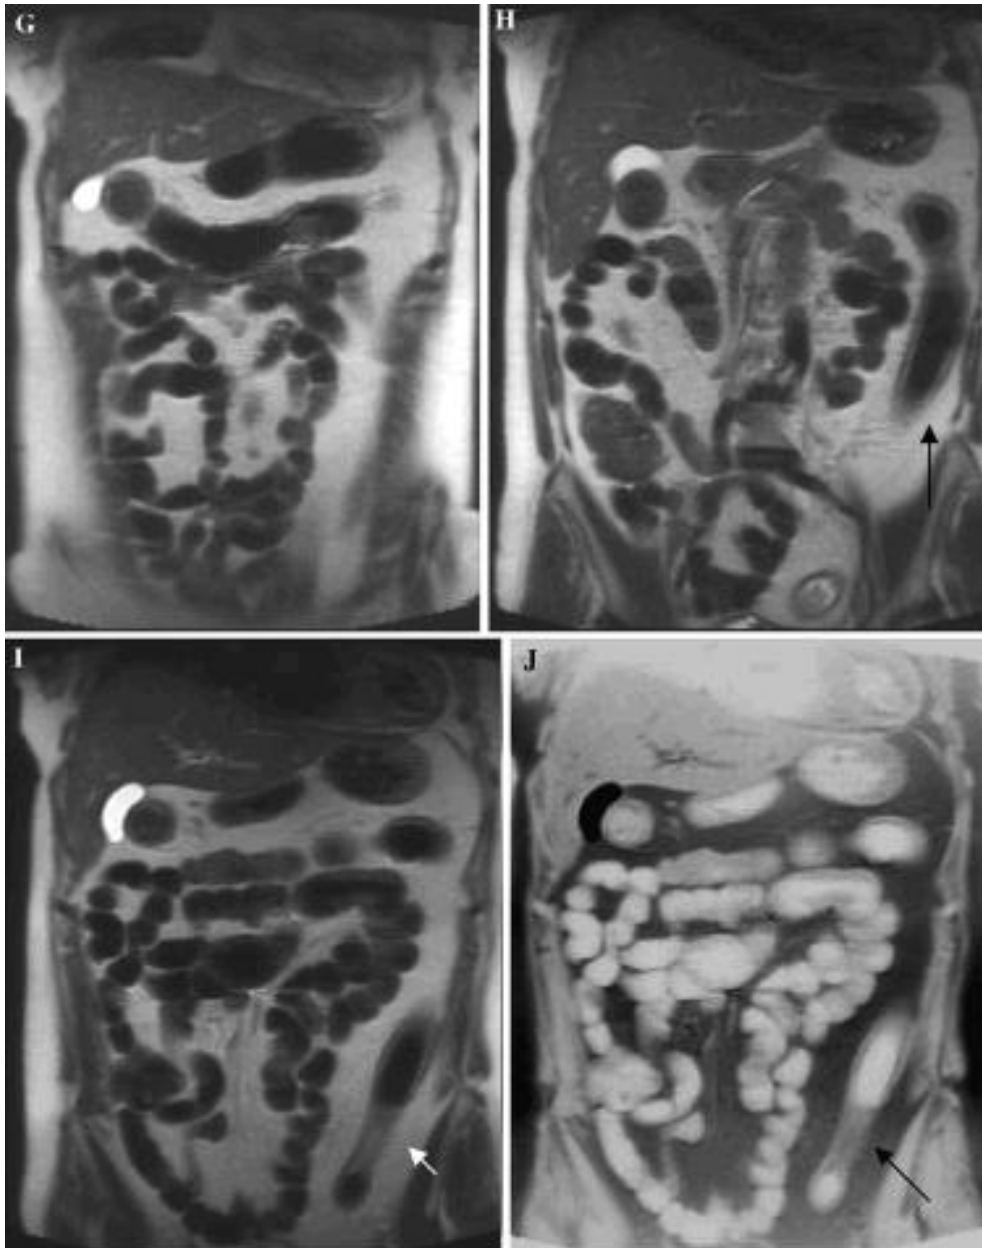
A 55-year-old man, with colonic CD and clinical instrumental signs of high disease activity (endoscopic signs of colonic active disease, increased serum signs of activity, CDAI > 150). Double contrast MRI was obtained after oral administration of 1000 cc of oral SPIO contrast agent. A, B T1-weighted coronal fat-suppressed VIBE images, following Gd-injection: increased wall thickening and marked wall enhancement at the level of the descending-sigmoid colon (arrows). Mild enhancement of the right colon-distal ileum. Normal small bowel. C, D T1-weighted axial FLASH plain image (left), showing wall thickening and fibrofatty proliferation at the level of the descending colon. Susceptibility artefacts at the level of the bowel loops. On the right side, axial VIBE T1-weighted image, following Gd-injection, at the same level: a marked wall thickening and Gd-enhancement ("double-contrast" effect) is clearly evident, due to darkening of the bowel lumen (white arrow). E, F T2-weighted HASTE plain image (left), and fat-suppressed image (right), both showing wall thickening and fibrofatty proliferation at the level of the descending colon (black arrow). On the left image the diffuse wall brightness ("double contrast" effect) suggests marked wall edema (white arrow). G, H Coronal T2-weighted images. The bowel is diffusely and homogeneously darkened due to the negative contrast agent. Inflammatory involvement of the transverse colon and, more severely, of the descending colon (arrow) can be diagnosed, on the basis of diffuse wall thickening, lost of haustration and fibrofatty proliferation. I, J Coronal T2-weighted image (left): The bowel is diffusely and homogeneously darkened due to the negative contrast agent. Inflammatory involvement of the descending colon is clearly evident (arrow). On the right side, the same inverted coronal plane: the homogeneity of the intestinal contrast can be well appreciated on the right side.
